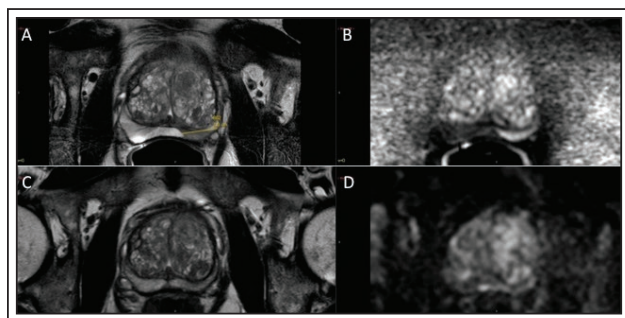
A to B, initial T2-weighted (T2W) mpMRI (A) and diffusion-weighted (DWI) mpMRI (B), demonstrating a 2.1 cm PI-RADS 5 lesion in the left apical mid peripheral zone; C to D, repeat T2W (C) and DWI (D), characterized as PI-RADS 1, exhibiting complete disappearance of the PI-RADS 5 lesion.
